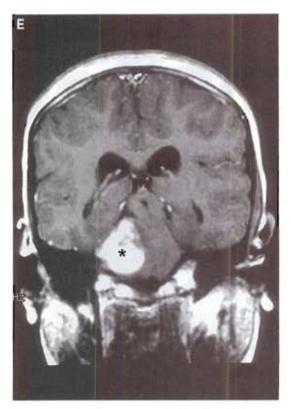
A. Noncontrast axial short TR MR image revealing a hypointense giant right petro-clival CPA tumor (*) (TR 400/TE 16/NEX 1); B: Same image after contrast enhancement revealing a brightly and homogeneously-enhancing tumor (*) (TR 400/TE 16/NEX 1); C: A long TR un-enhanced MR image revealing a hyperintense CPA tumor (*) (TR 2500/TE 30/NEX 0.75); D: Postoperative contrast-enhanced axial MR image demonstrating gross total tumor removal. Note the fat graft (*) placed in position of drilled petrous bone (TR 400/TE 16/NEX 1), E. Coronal contrast-enhanced short TR MR image revealing a brightly homogeneously-enhancing CPA tumor (*). Note the brain stem compression (TR 400/TE 16/NEX 1) F: Post-contrast postoperative coronal short TR MR image confirming gross total tumor removal and relief of brain stem compression. Note the fat graft (*) placed in position of drilled petrous bone (TR 400/TE 16/NEX 1)
